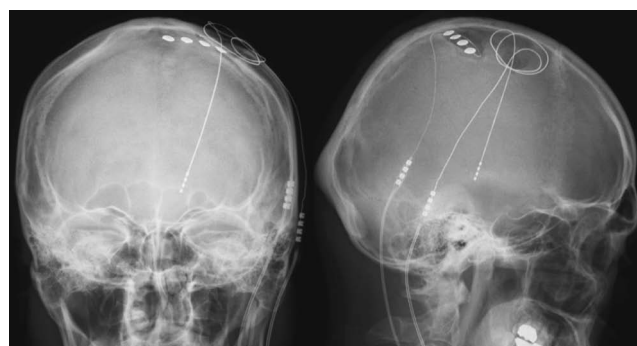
Case 10. Radiographs showing placement of the electrode array in the left precentral gyrus and the deep brain-stimulating electrode in the left ventrocaudal nucleus of the thalamus.
